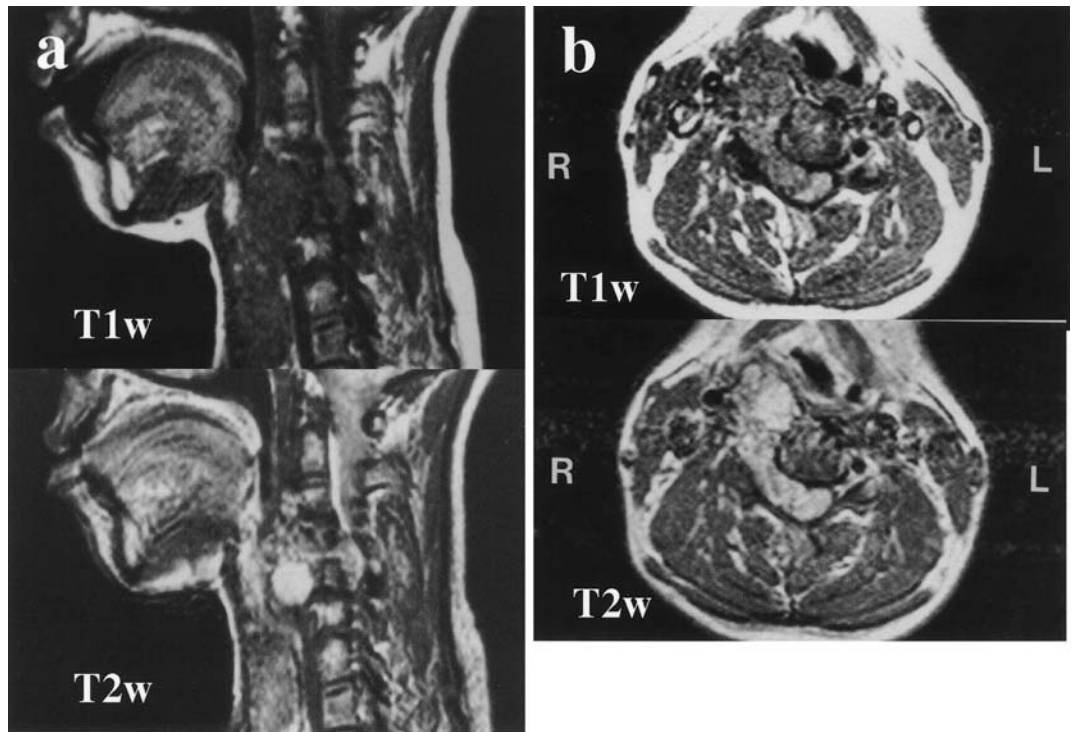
Sagittal (a) and axial (b) magnetic resonance imaging (MRI) scans of the cervical spine. T1-weighted image (*T1w*) shows the tumor as areas of low signal intensity and T2-weighted images (*T2w*) as areas
